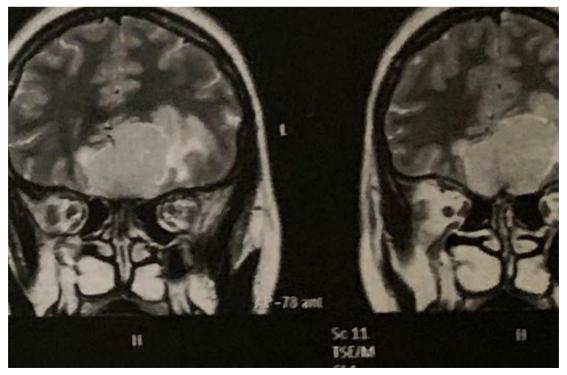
Magnetic resonance imaging of the brain, T1-weighted coronal section, demonstrating a solid extra-axial expansive process (meningioma) vascularized in the frontal basal plane of the olfactory groove and planum sphenoidale.
